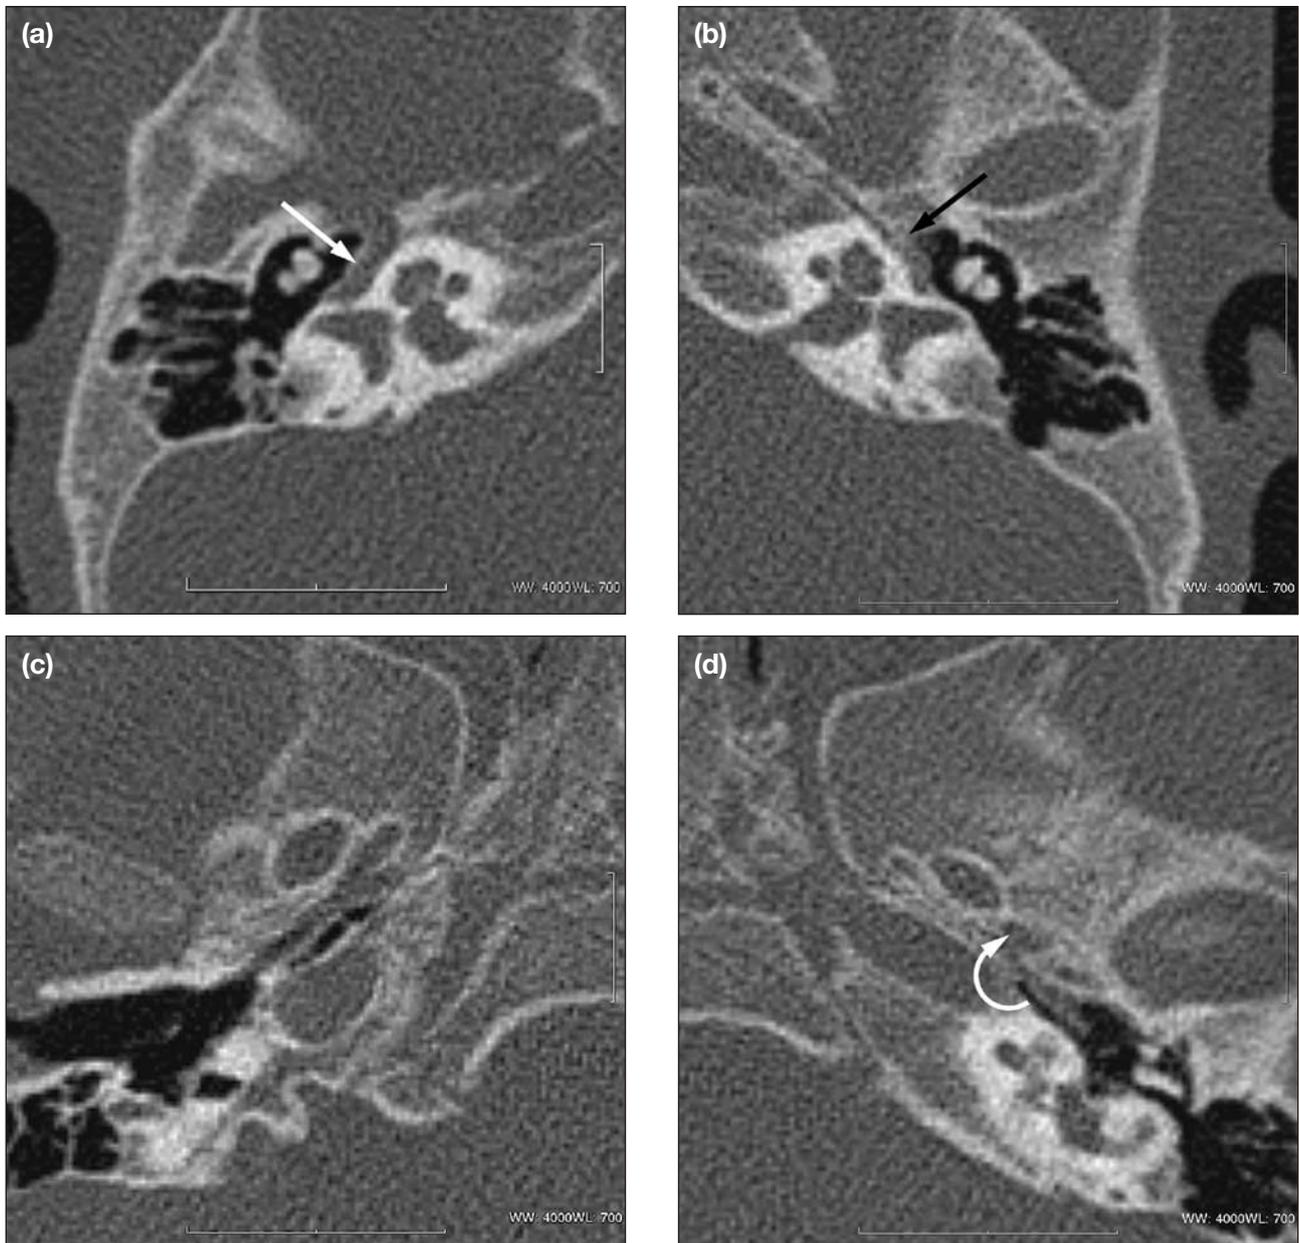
Axial computed tomography images of (a and b) the temporal bone at the level of the cochlea showing widening of the right facial nerve canal (white arrow) compared with the left facial nerve canal (black arrow); and (c and d) the skull base level showing absence of the right foramen spinosum, compared with the normal left foramen spinosum (curved white arrow).
